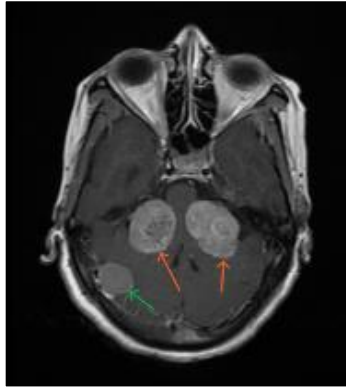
Axial T1+C image of MRI brain showing large heterogeneously enhancing lesions (orange arrow) at bilateral cerebello-pontine angles causing its compression. Also note the presence of a meningioma in posterior fossa (green arrow)
